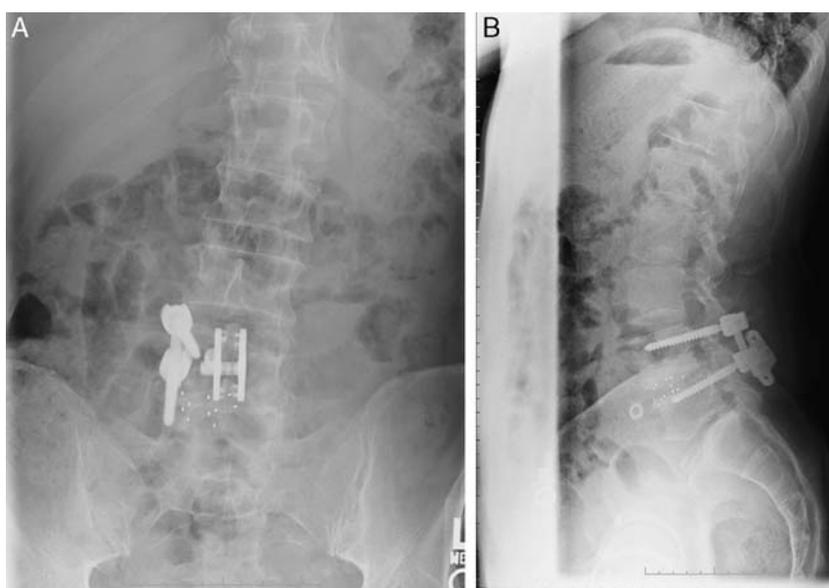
Postoperative anteroposterior (A) and lateral (B) radiographs demonstrating the Aspen device and unilateral pedicle screws.
